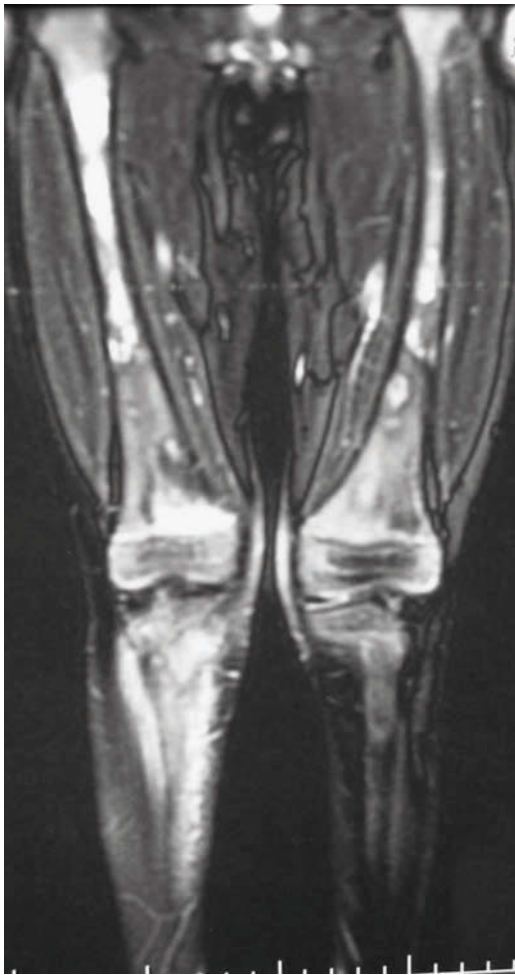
MRI image of the lower limbs: abnormal marrow signal intensity that mainly affects the distal femoral metaphysis, proximal fibular metaphysis and right tibia, with bilateral femoral shaft involvement.
